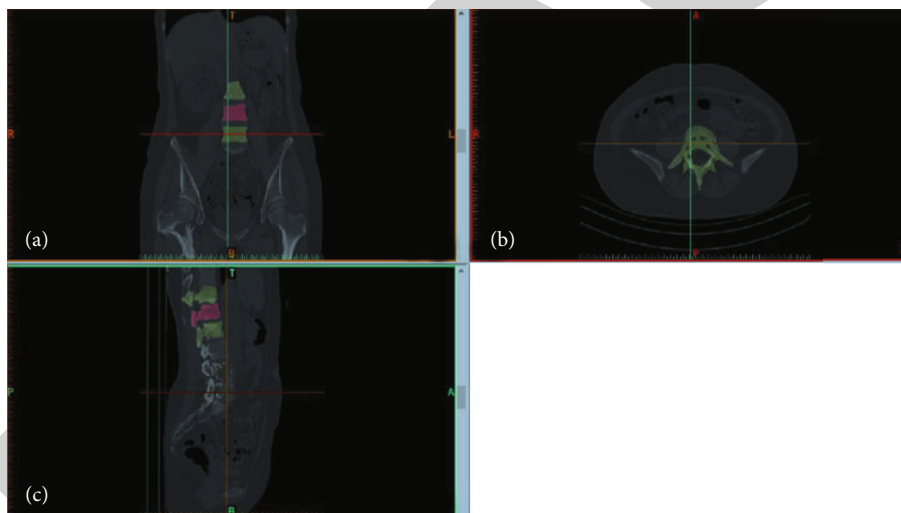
CT imaging of the spine of a healthy male ((a) the coronal plane, (b) the cross section, and (c) the sagittal plane).
